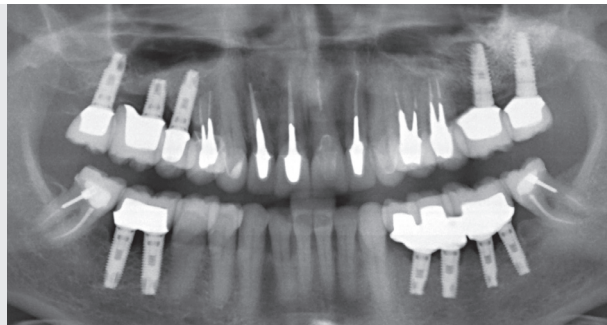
Final X-ray: The inclination of the implants was also improved with the customized superstructures and crowns.
